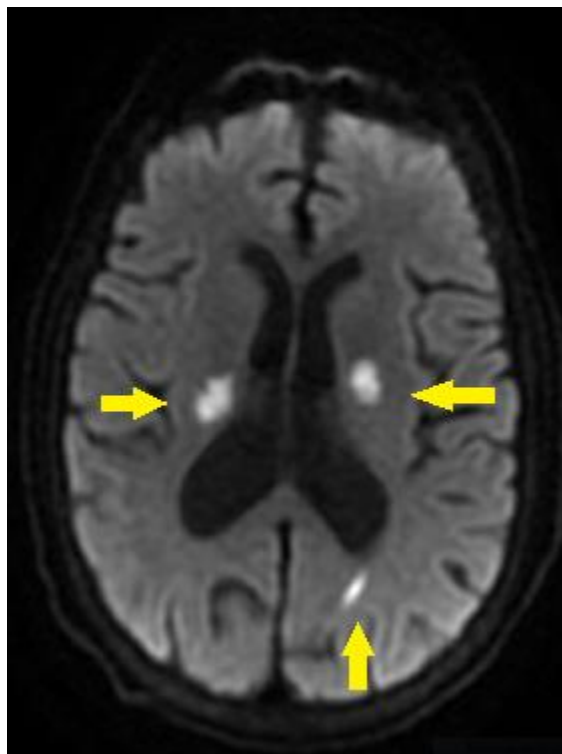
MRI brain showing bi-hemispheric acute infarcts (yellow arrows).
